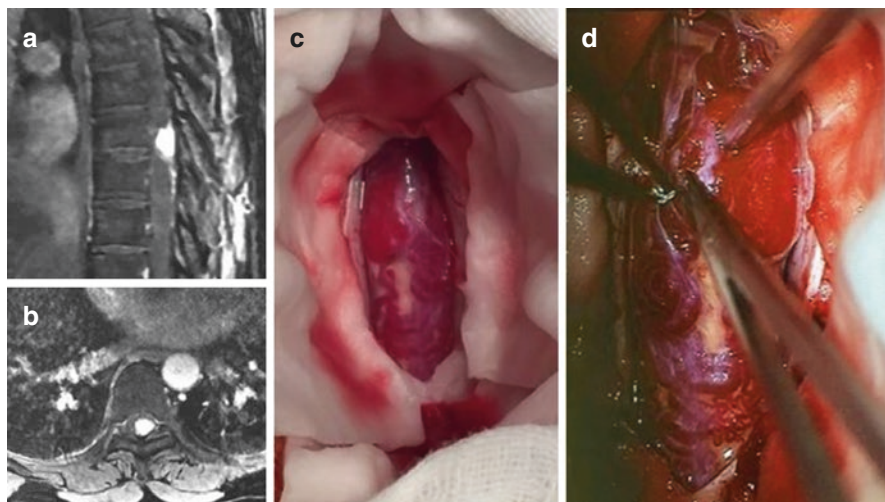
Coronal (a) and axial (b) MRI with gadolinium identifying intramedullary hemangioblastomas of the thoracic spinal cord. Intraoperative view of the hemangioblastomas (c, d)
